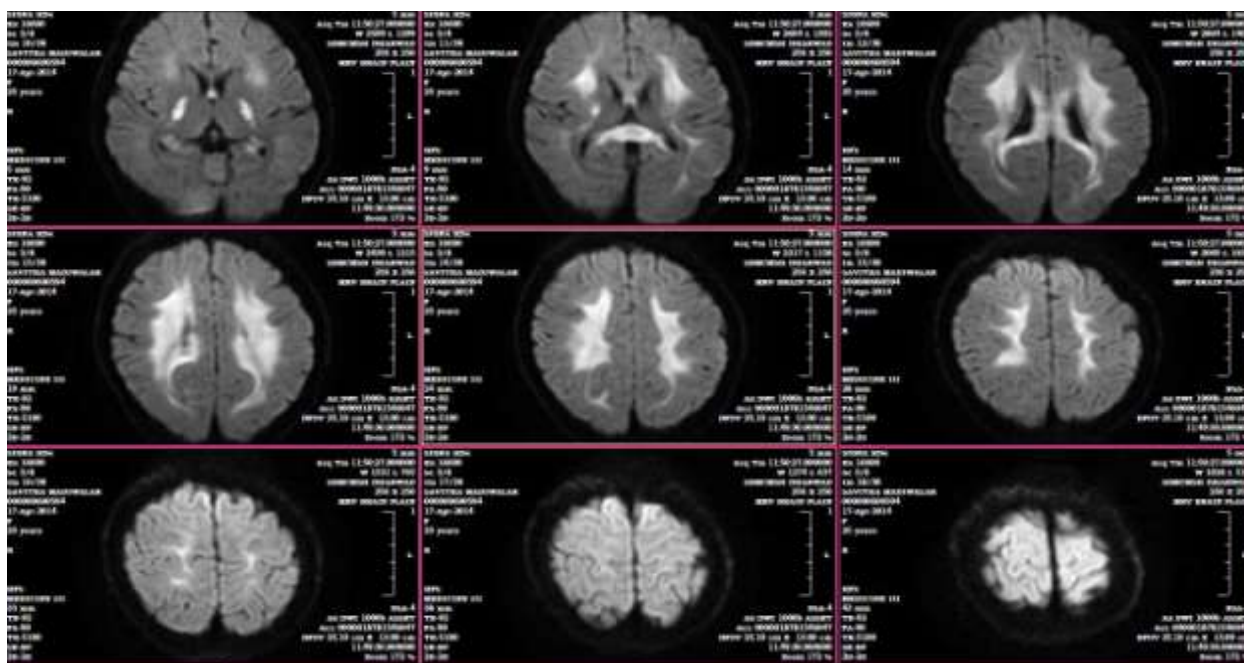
MRI brain findings were attributed to hypernatremic encephalopathy
